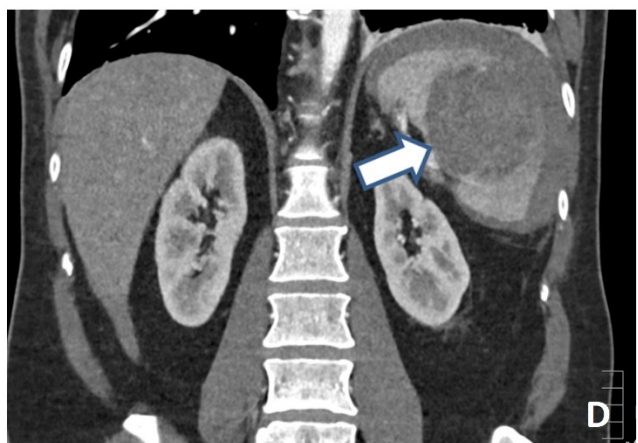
Contrast enhanced abdominal CT shows a perisplenic effusion measuring approximately 16 mm, hyperdense in the basal phase, consistent with recent blood (indicated by arrowhead, panel A). Following the administration of contrast medium, a large intraparenchymal hematoma measuring approximately 6.8 x 7 cm becomes visible (indicated by arrow, panel C and D) without arterial blush. Portal phase is showed in panel B.
